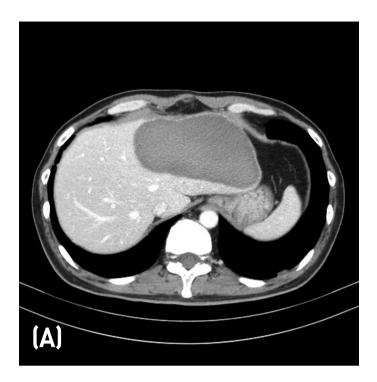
(A) Follow-up abdominal computed tomography showing subtle decrease in the size of the subscapular hepatic hematoma (14.9 cm from 17.8 cm, in axial size) in the left lobe of the liver and no abnormal fluid collection, (B) Abdominal X-ray showing percutaneous insertion of an abdominal drainage catheter into the subcapsular hepatic hematoma
